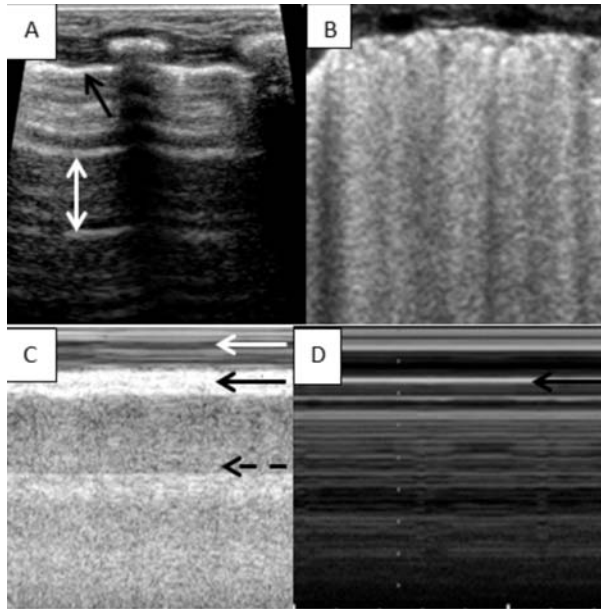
(A) Normal lung ultrasound- Horizontal A lines shown by the white arrow equidistance from each other and the pleural line, black arrow showing the pleural line (PL). (B) Multiple vertical lines starting from the PL and almost coalescing with each other giving a white lung appearance. (C) Normal lung M mode- Seashore sign, black arrow denoting PL, white arrow showing the chest wall looking like water and the broken black arrow showing lung parenchyma looking like a sandy beach. (D) Stratosphere sign as seen in pneumothorax, there is no water and sandy part, it all looks like water.
